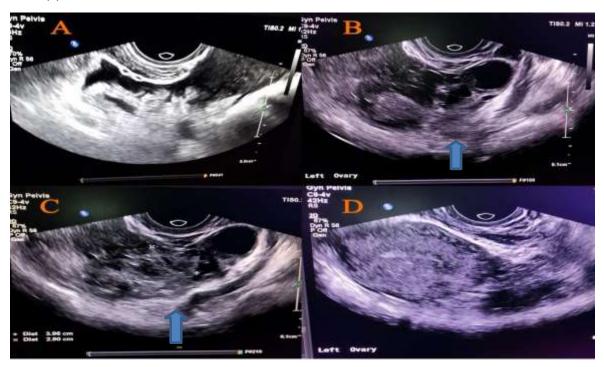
Transvaginal sonographic images of female patient 31 years old presented with acute left iliac fossa pain and vaginal spotting as well as positive BHCG revealed: Mild amount of free fluid noted in the pelvis (A), left adnexa shows rather defined heterogeneous mainly hyperechoic lesion measuring about (3.8x2cm) that couldn't be totally separated from the left ovary (B,C) (blue arrows). Uterus shows thickened endometrium with no visible intrauterine sac (D), no fetal pole noted. It was diagnosed as left adnexal disturbed ectopic pregnancy.
